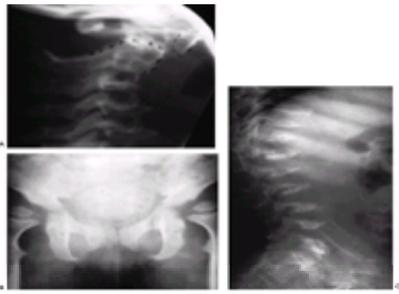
Morquio syndrome. The radiographic features include an absent odontoid (A), a pelvis with capacious acetabuli and coxa valga (B), and a marked platyspondyly at 12 years of age (C). It is difficult to imagine these vertebrae were normal at birth.
